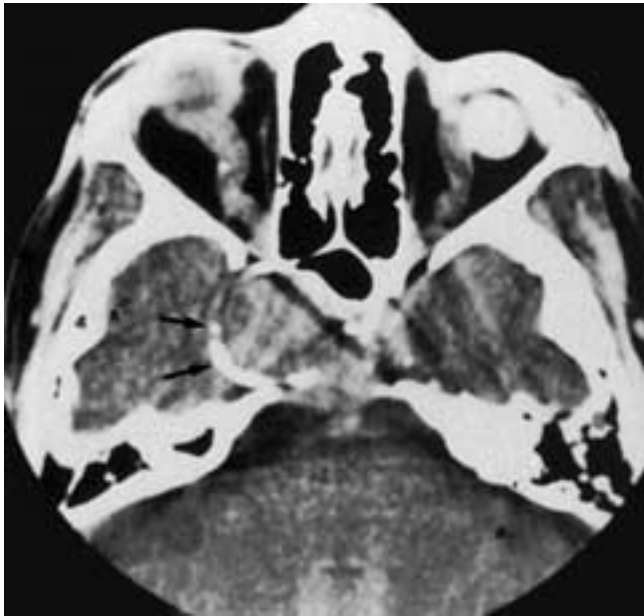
Intracavernous aneurysm. Plain axial CT image shows a mass with peripheral calcification (arrows) that is eroding the sphenoid bone and sella turcica.
